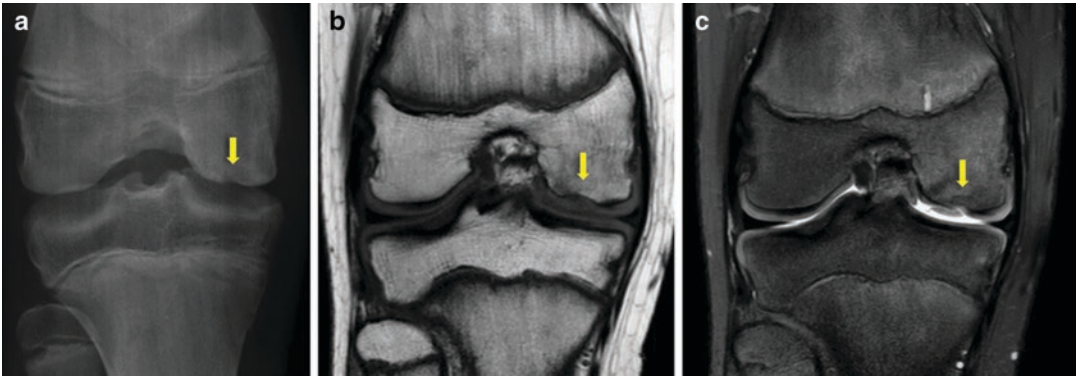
(a)—X-ray, (b)—Coronal T1 MRI, and (c)—Coronal PD Fat Sat MRI. Arrow: irregularity on the medial condyle of the femur, suggesting Osteochondritis Dissecans
